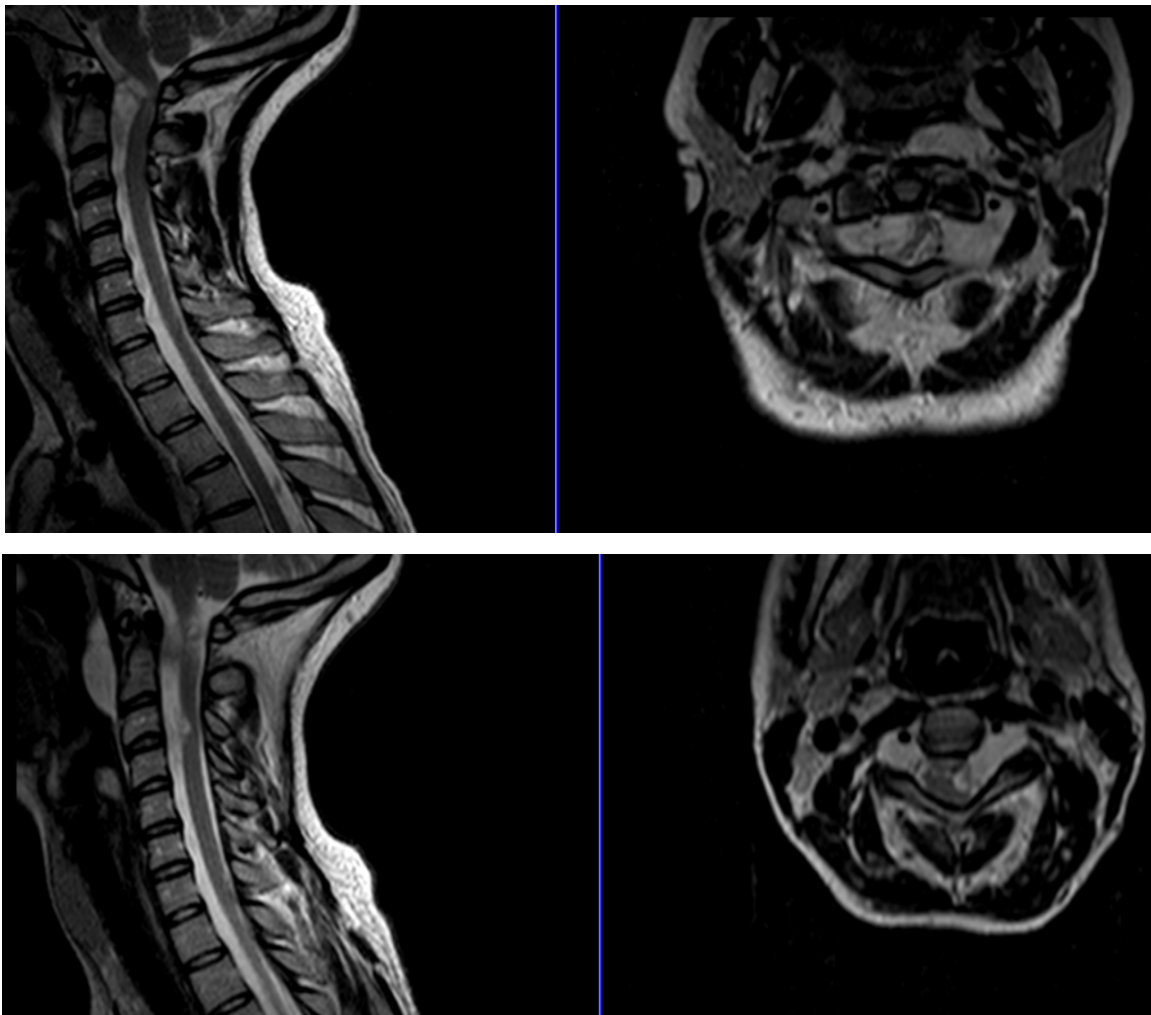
MRI revealing bilateral C2 root tumor with severe bilateral spine cord compression and C3 unilateral tumor.
